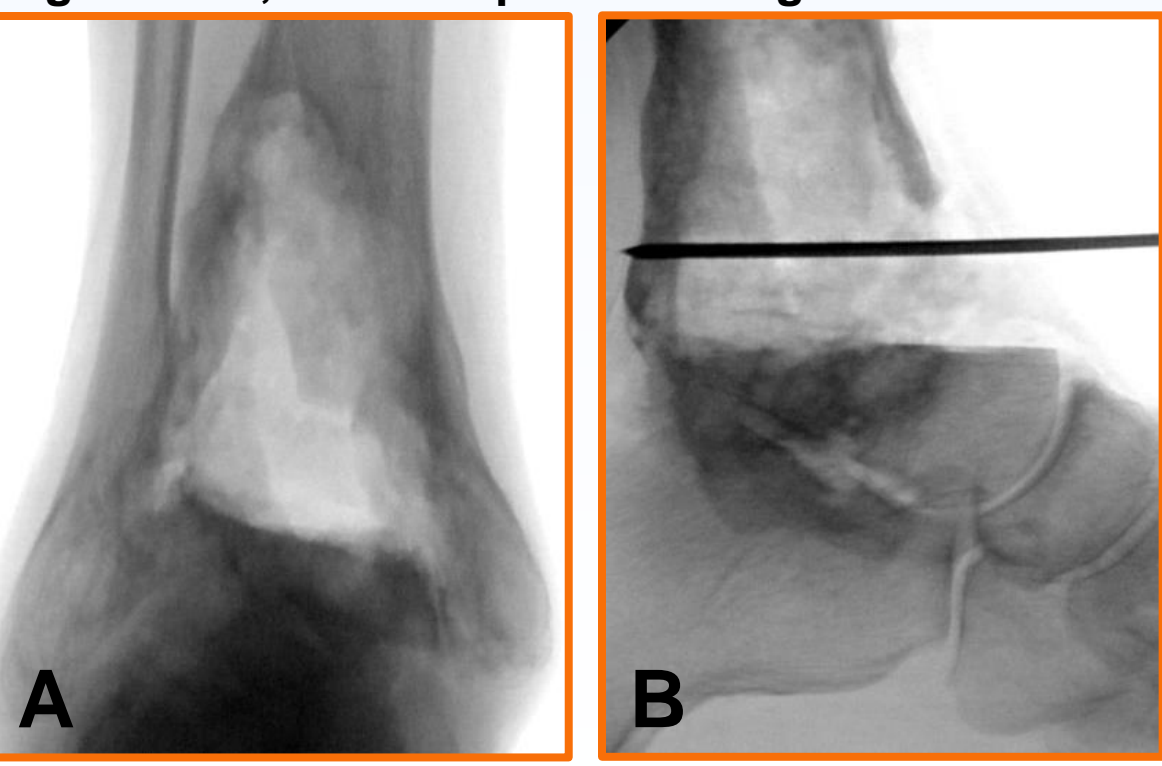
C - Preoperative CT
